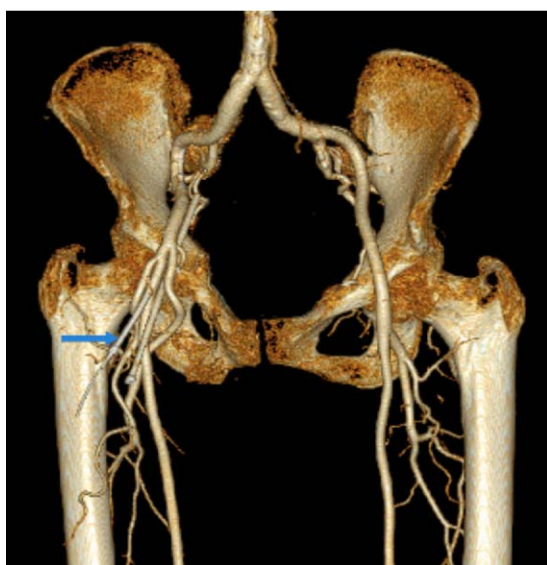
3-Dimensional Image From CT Angiogram
